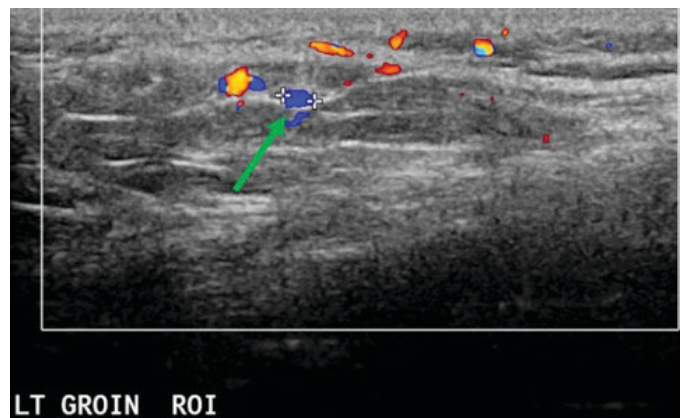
Color Doppler ultrasound image demonstrating thrombosed varicocele.
